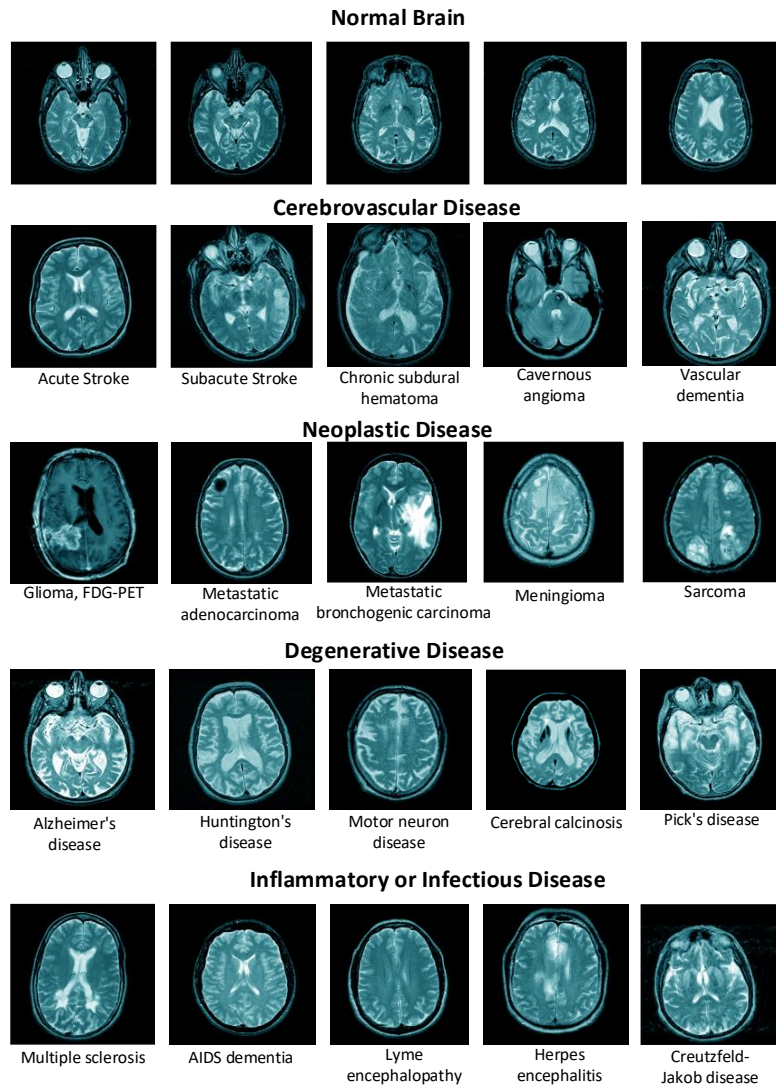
Sample brain MR images of five classes of this study.
